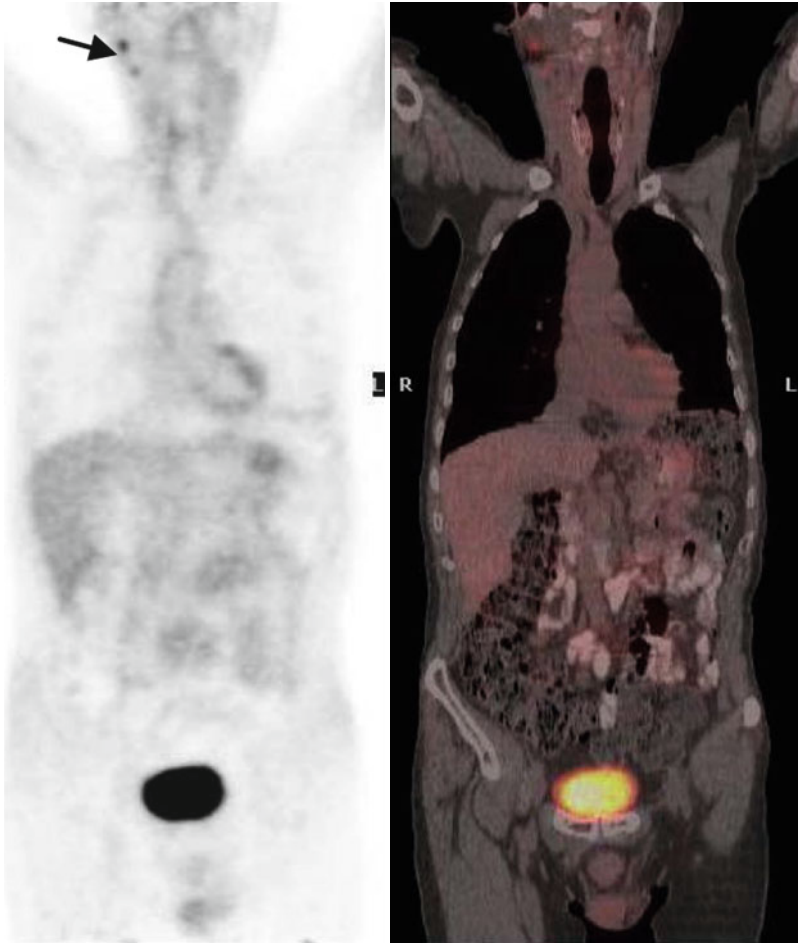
Three months after ASCT, PET/CT shows hypermetabolic lymph nodes in the right parotid and at the upper right cervical area (*arrow*)
